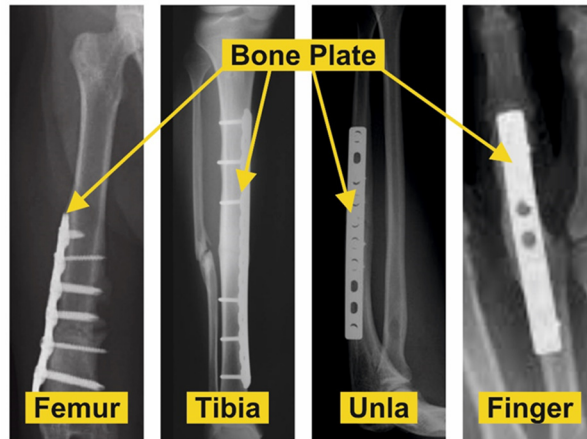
Example X-ray images of broken bones fixed with bone plates
